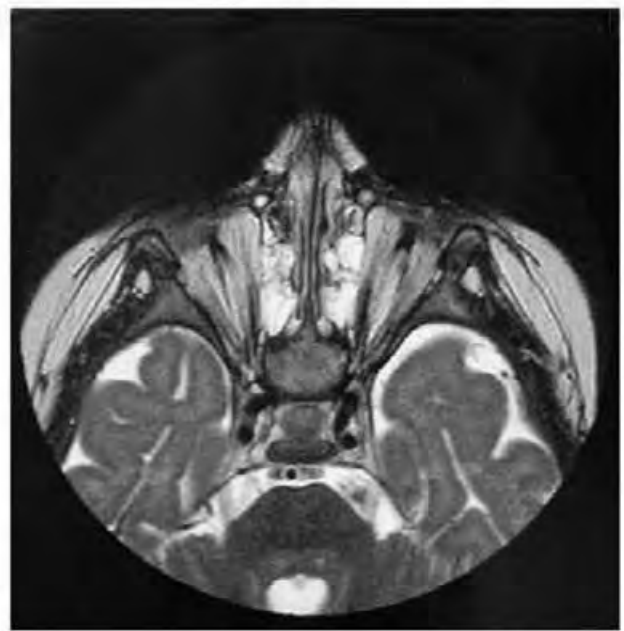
Magnetic resonance imaging scan of the proband. Note absence of ocular structures replaced by fibrous tissue.
